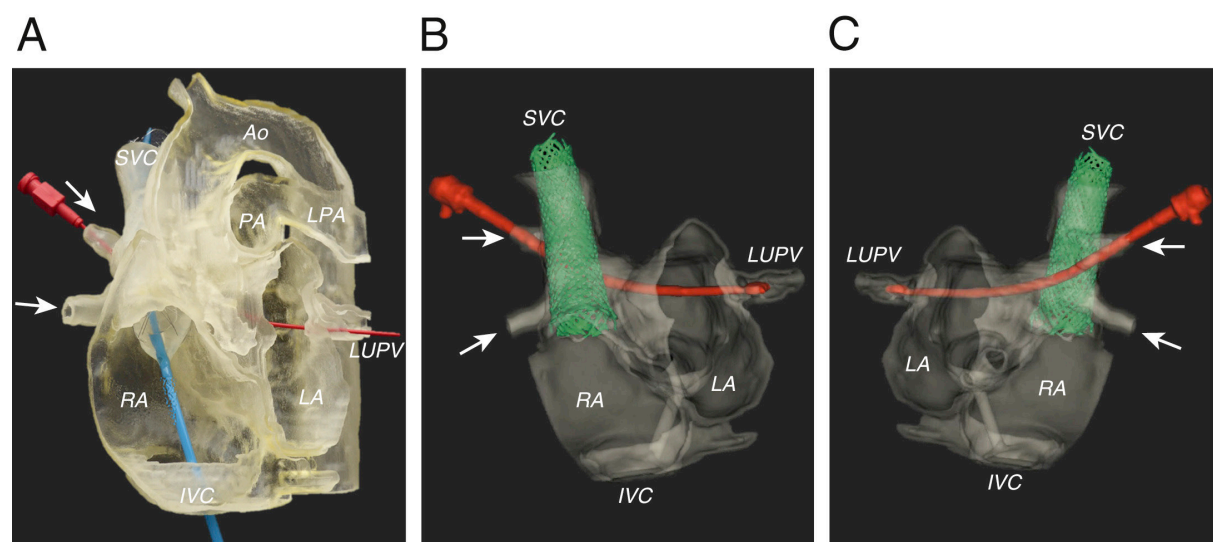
The flexible, translucent model (A) was examined to assess the relationship of the anomalous PVs (arrows) to the SVC and LA. A balloon-mounted stent catheter was placed in the SVC to RA junction (blue catheter), while a dilator (red) was passed from the anomalous right upper PV to the left upper PV. This model allowed for calculation of the length of the stent required to close the defect and redirect the flow of the partial anomalous pulmonary venous drainage toward the LA. CT of the model was performed using 3D rotational X-ray acquisition, shown from anteroposterior (B) and postero-anterior views (C) (dilator in red; stent in green). Reprinted with permission from Velasco Forte *et al.*^[18]. PV: pulmonary vein; SVC: superior vena cava; LA: left atrium; RA: right atrium; CT: computed tomography; 3D: three-dimensional
